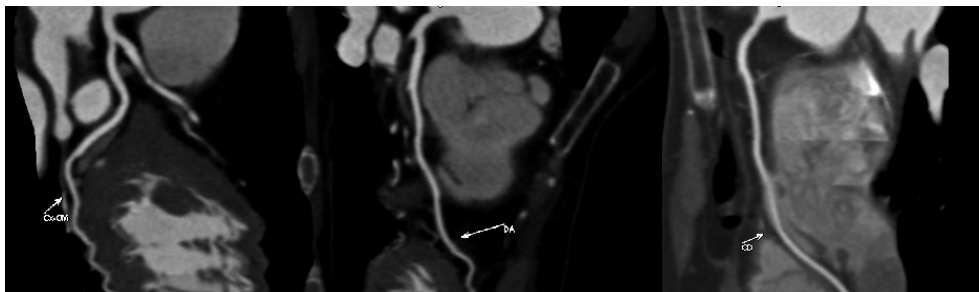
Example of normal coronary angiographic multidetector CT image in a patient without coronary atherosclerosis. Curved multislice reconstructions of the circumflex (left), left anterior descending (middle) and right coronary artery (right) in a patient with normal coronary arteries.
